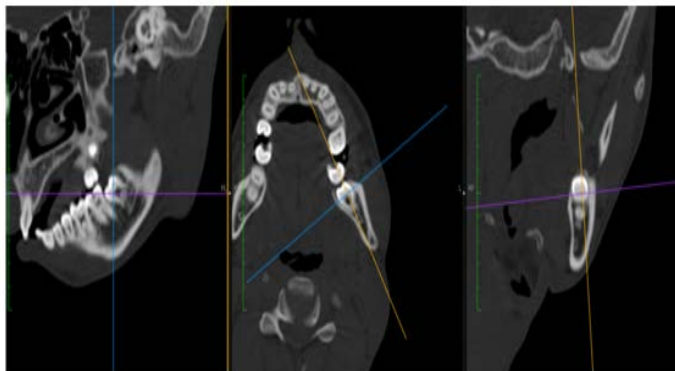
3D CT scan imaging of third molar with various axes
